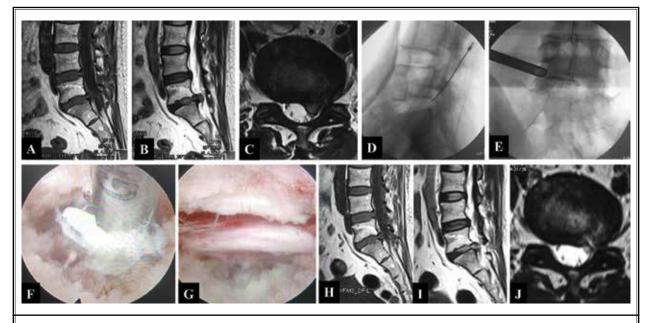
Preoperative T1-weighted sagittal (A), T2-weighted sagittal (B), and axial (C) MRI of a woman aged 52 years who complained of left leg radiating pain, showed L5-S1 disc herniation with Modic type 2 signals in the bone marrow. Intraoperative radiography showed an endoscopic working channel (D-E). Intraoperative endoscopic view showed the herniated disc was removed using endoscopic forceps (F), and complete decompression the left S1 nerve root (G). Postoperative T1-weighted sagittal (H), T2-weighted sagittal (I), and axial (J) MRI showed the decompression of nerve root and removal of the herniated disc at the L5-S1 level.
